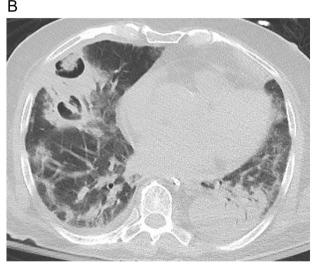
Axial CT images in a 73-year-old male patient diagnosed with probable COVID-19-associated pulmonary aspergillosis and atypical CT appearance for COVID-19 with cavities. CT images show multiple large cavities with thick irregular or smooth walls in the left upper and right middle lobes (A–B). Debris exist in the cavities of the right middle lobe. Poorly defined solid nodules (arrow) and centrilobular nodules (within circle) are noted in the right upper lobe (A).
